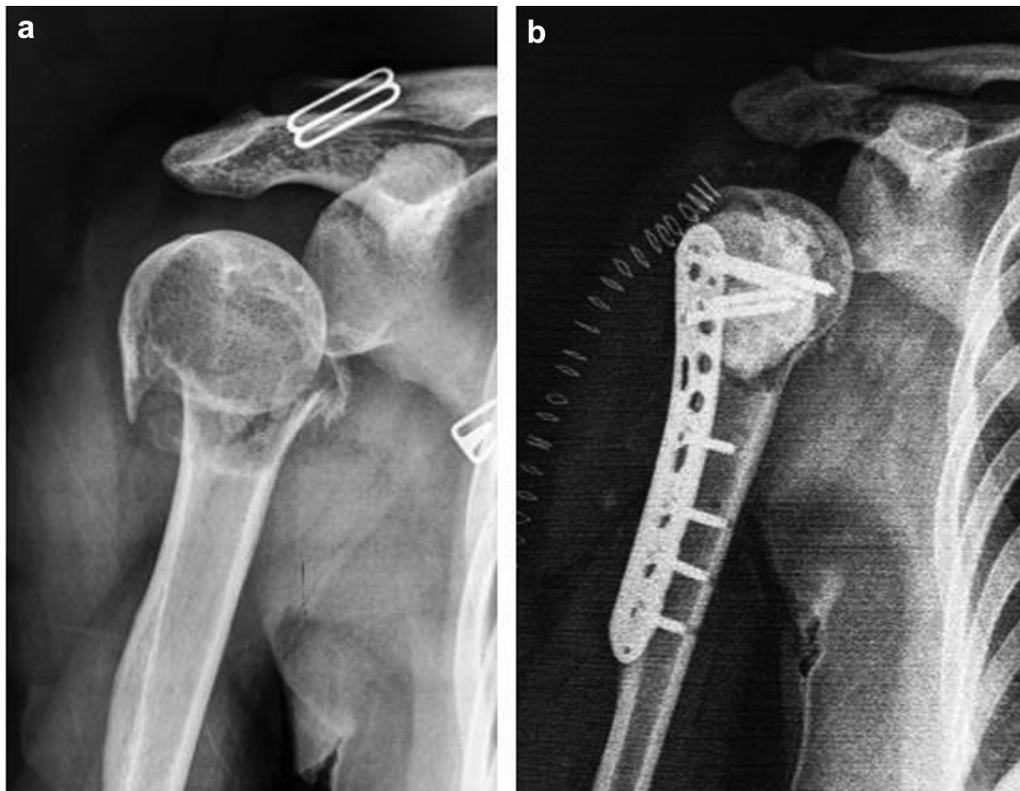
Right-sided Campanacci grade II proximal humerus giant cell tumor in a 36-year-old woman (case 14 in [Table I](#)). (a) A preoperative radiograph shows fracture displacement. (b) A postoperative radiograph shows that the bone cement and internal fixation are in good position.
